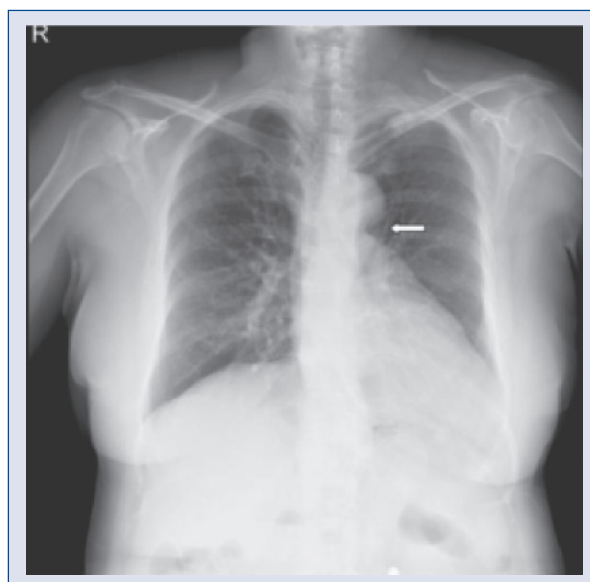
Chest radiograph showing leftward position of the heart, flattening and elongation of left heart border (so-called ‘Snoopy sign’), and a lucent area between the aorta and pulmonary artery due to lung interposition (white arrow).
